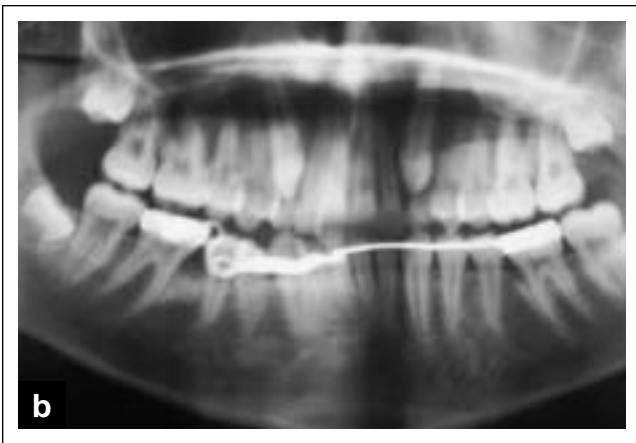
Radiographic post-treatment records.
